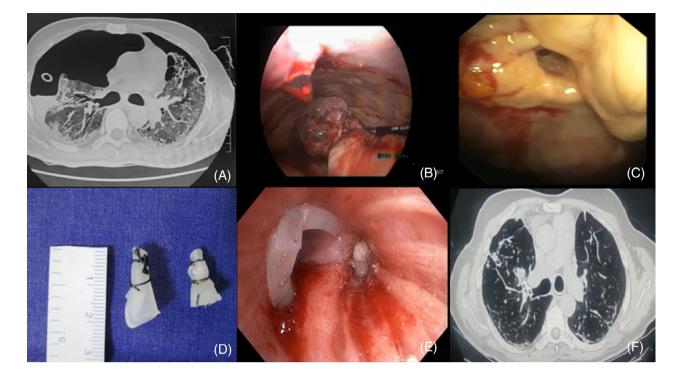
(A) CT scan showing b/l fibrocystic changes with ICD in situ. (B) Left VATS showing bullous lesions with stapler in situ. (C) Right pleuroscopy showing right upper lobe posterior segment fistula. (D) Customized endobronchial silicone blockers ex-vivo. (E) RUL showing CESB devices in situ. (F) Follow up CT scan showing resolution of pneumothorax.
